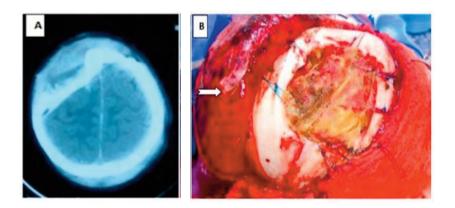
Head CT (A) showing axial section of a right fronto-parietal skull depression fracture. Intraoperative view (B) of the lifting of the skull depression fracture, arrow indicating the patient's forehead.
